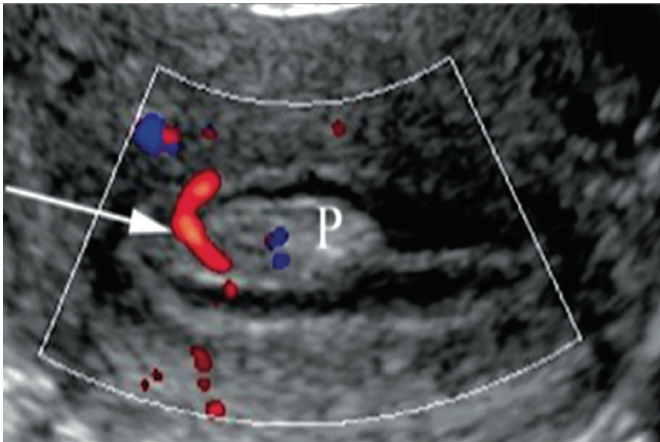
Doppler ultrasound: solitary, smooth, well-defined and uniformly echogenic pedicled endometrial polyp (P), originating from the anterior wall with vascular pedicle (arrow), in a 40-year-old woman.<sup>17</sup>
